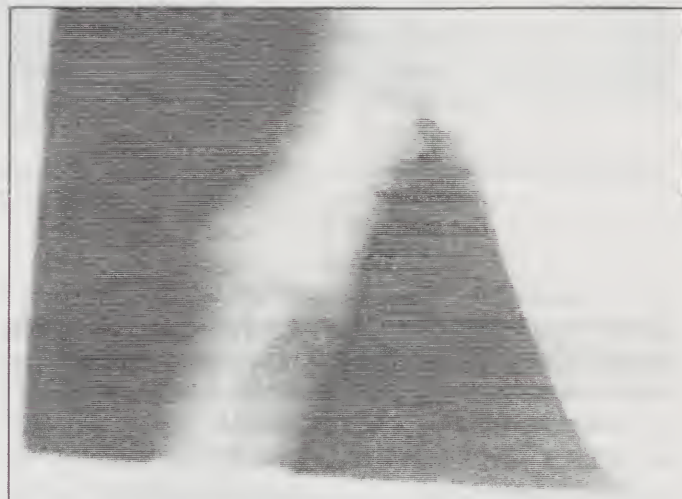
A-P roentgenogram of left upper extremity, demonstrating the soft mass, without joint or bony involvement.
